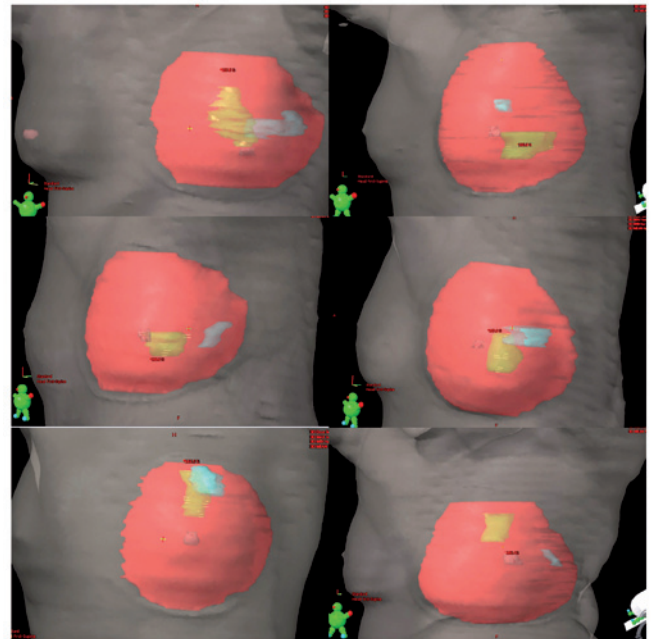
CT image fusion showing the cavity shift. The cyan coloration shows the preoperative gross tumor volume; red, breast clinical target volume; green, lumpectomy cavity; yellow, surgical clips; brown, nipple.
